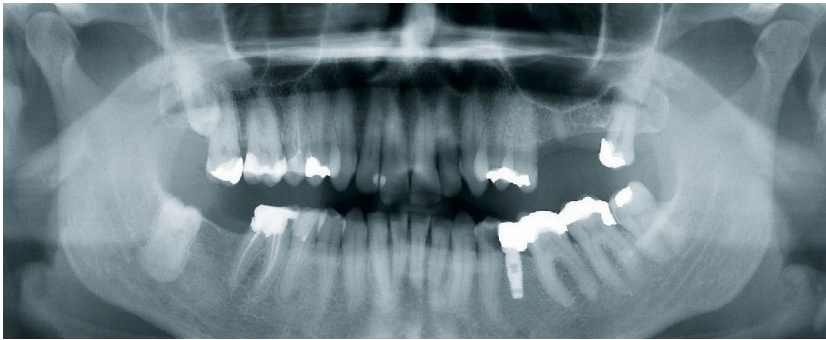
Preoperative panoramic radiograph. Tooth 34 shows an extensive carious lesion distally.
